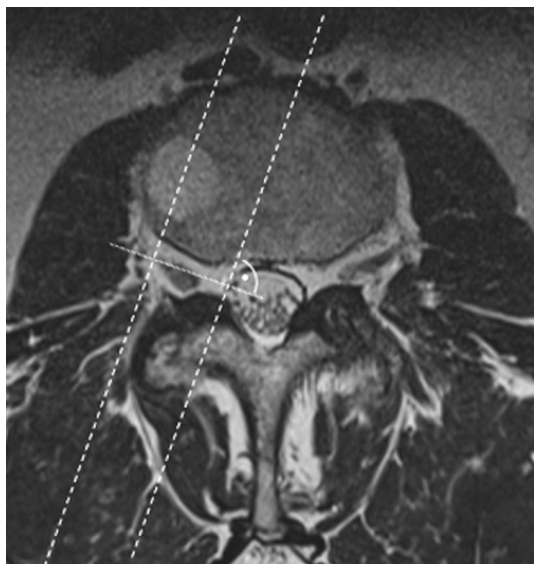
Axial T2-weighted magnetic resonance imaging (MRI) for planning the parasagittal constructive interference in steady state (CISS) sequence at the level of the nerve root; the slices were aligned perpendicularly to the course of the intervertebral foramen; incidental right paramedian vertebral body hemangiomas
